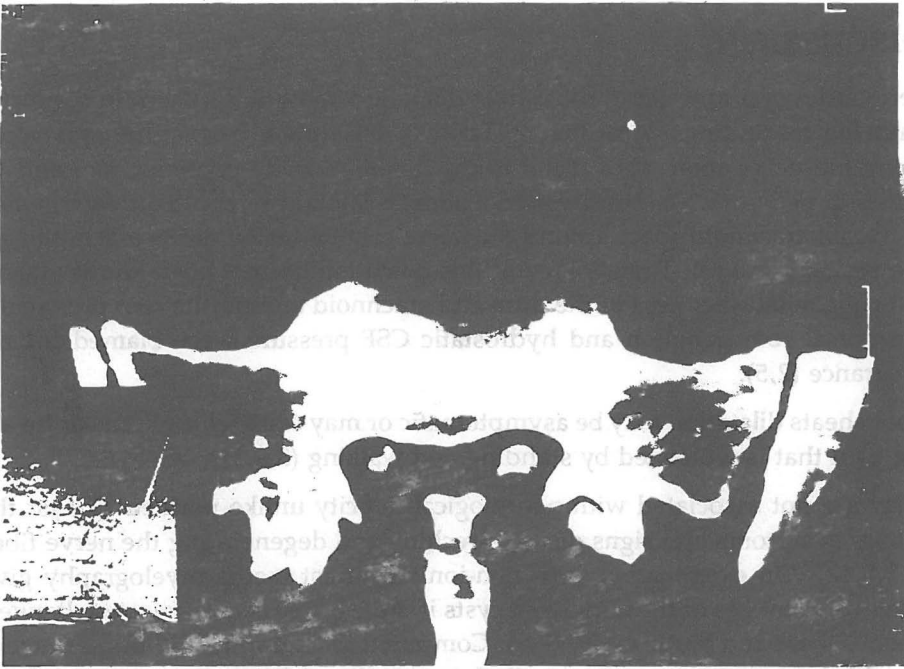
Computed tomography with Intratechal contrast media.
